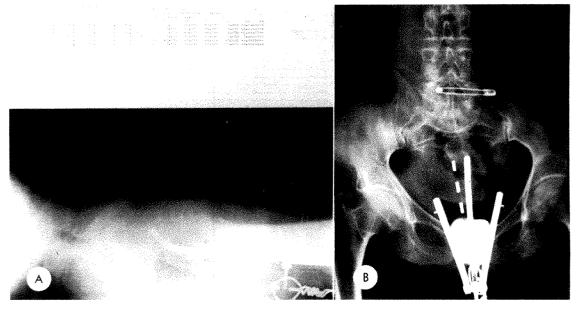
Typical carcinoma of cervix radium 226 application No. 1. (A) Lateral and (B) anteroposterior roentgenographic projections.
